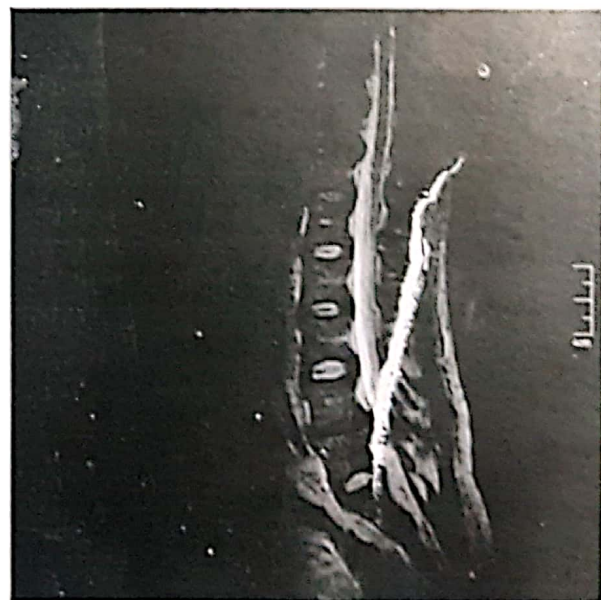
Sagittal Magnetic Resonance Imaging region of lumbosacral showing disc prolapsed.
